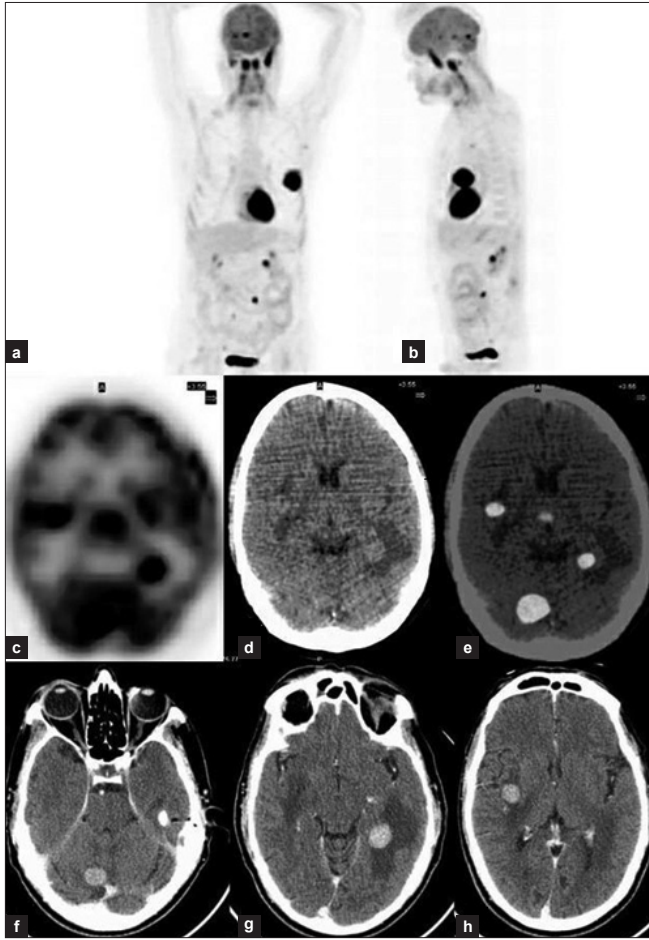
64-year male Ca left lung for staging; (a, b) Anterior and lateral MIP image showing left lung primary and small hyper-metabolic lesions in the brain; (c, d, e) Axial plain PET, CT and fused PET/CT images localize the foci to the left temporal, right cerebellar and right external capsule region corresponding to mildly hyper-dense lesions on LDCT; (f, g, h) Axial CECT slices clearly depicting the same lesions as intensely enhancing with surrounding edema
